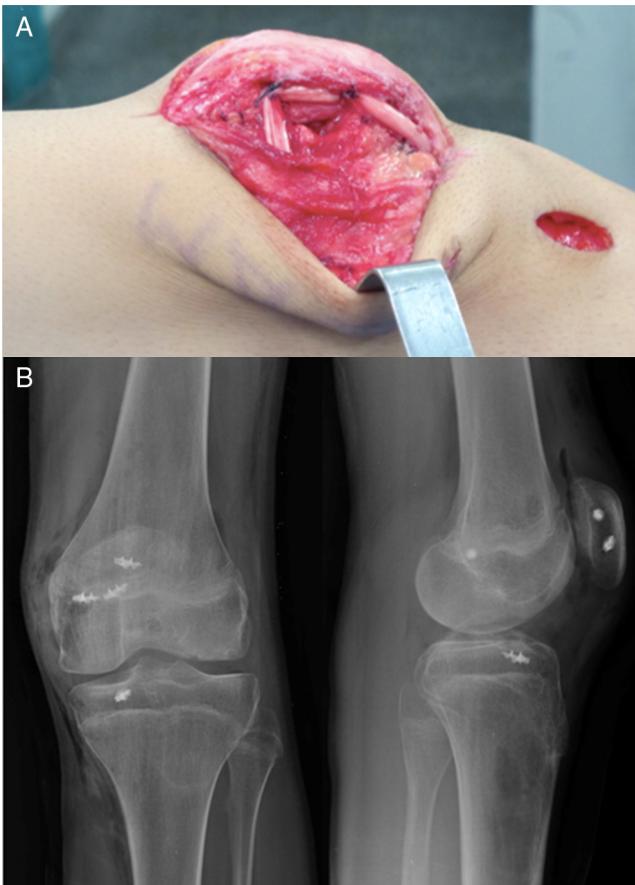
A, reconstruction of the patellofemoral and medial patellotibial ligaments; B, final radiographs after ligament reconstruction.
